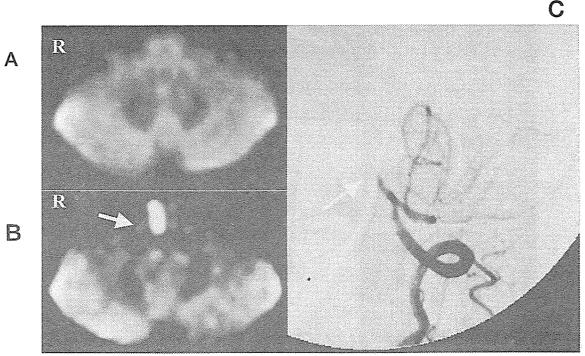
51歳男性,延髄梗塞の入院時の DWI と follow-up DWI
